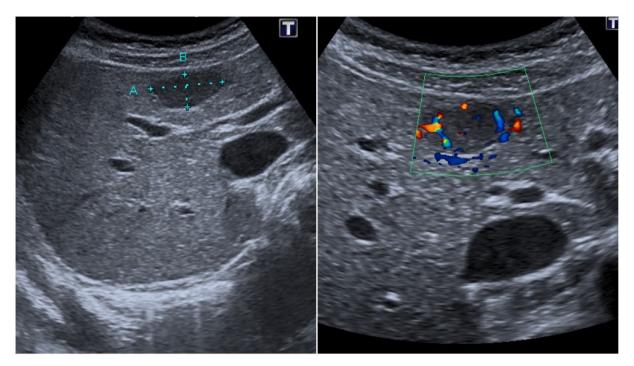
Ultrasound examination of the abdomen revealing well-defined, hypoechogenic incidental lession in the liver (a). Color dopler analysis demonstrates a hypervascularity of the lession (b).
